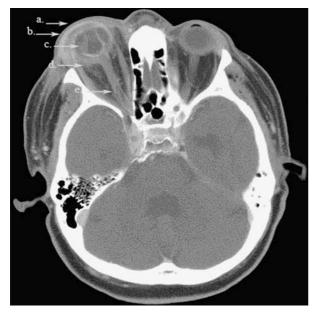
Orbital cellulitis: CT scan demonstrating OD (a) proptosis, (b) soft tissue inflammation, (c) choroidal detachment, (d) retrobulbar inflammation, and (e) optic nerve sheath enhancement. Figure has been digitally changed to incorporate arrows.
